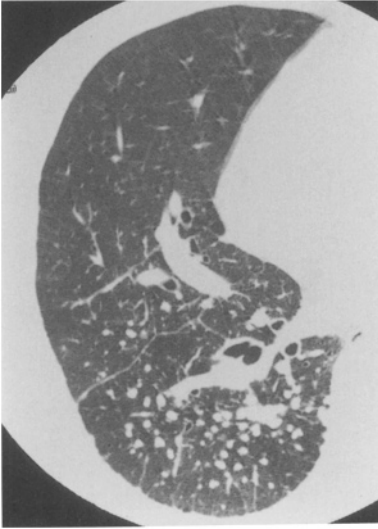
HRCT scan of q type opacities. Opacities of predominant q type are seen. These nodules are sharply demarcated and rounded
